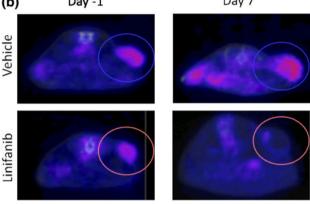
Tumor FDG uptake for vehicle and linifanib treatment over time. a FDG uptake is represented as SUV as a % of baseline. Significant differences are indicated by an *asterisk*. b Representative FDG-PET images for vehicle and linifanib treatment for baseline imaging and day 7 after treatment
